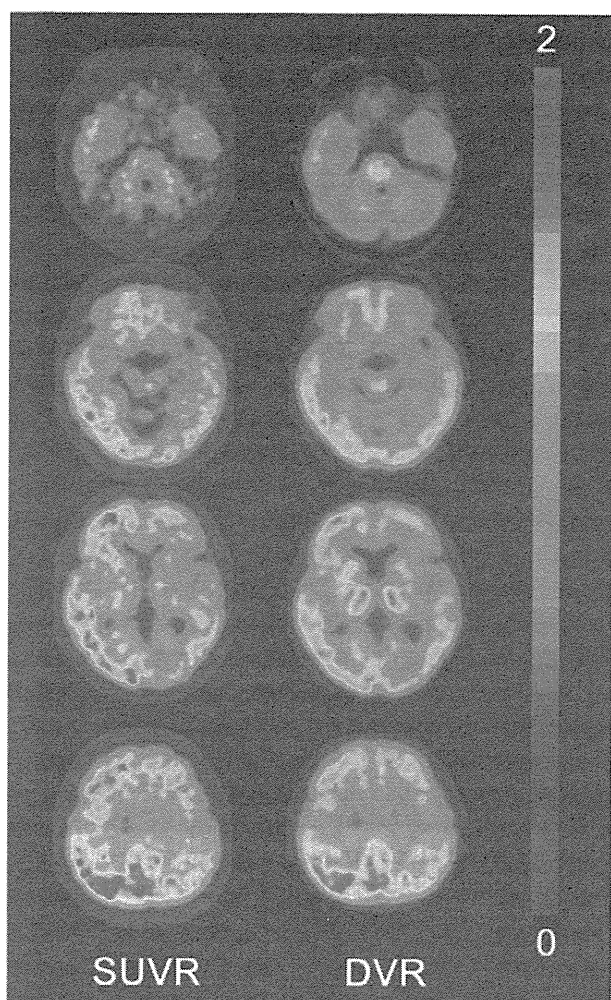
Comparison of SUVR and DVR images. DVR provides better image quality than SUVR. A longer period of approximately 70 minutes is required for data acquisition for DVR compared with 20 minutes for SUVR.
